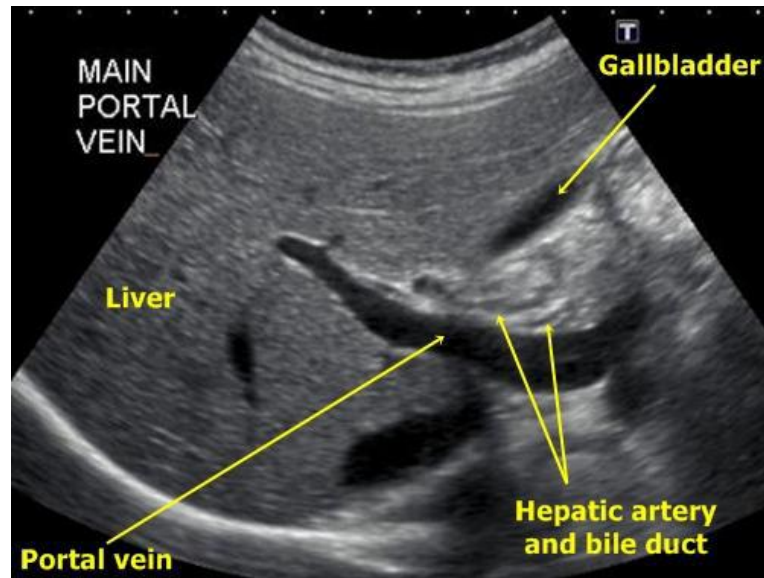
Ultrasound image shows the Portal vein (Zaka,et al 2011)
